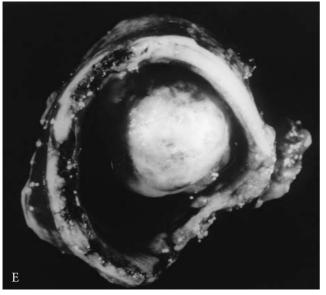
Carcinoid tumors. A, Bronchoscopic view. Carcinoids are often smooth, rounded, and vascular in appearance. B, Irregular carcinoid located just above the carina. C, Radiographic details of the carina of a 31-year-old woman treated for "asthma" with progressive dyspnea for over a year. Anteroposterior view on left radiograph and lateral view on right radiograph. Both show the lower tracheal tumor clearly.
